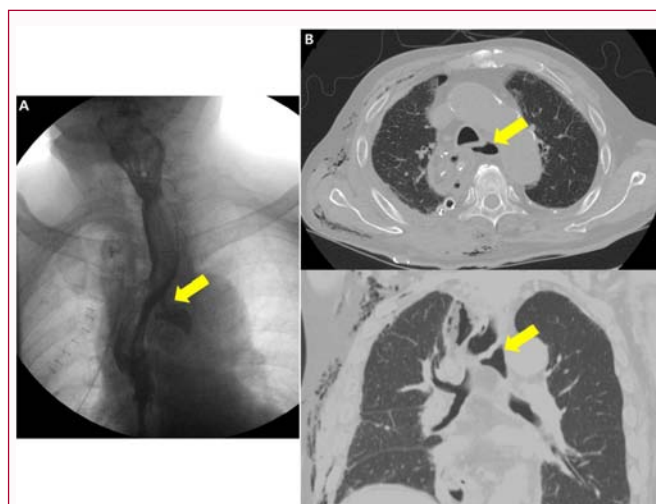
Radiologic images of esophageal anastomotic leak. (A) Water-soluble contrast esophagography confirming the presence of an anastomotic leak after an esophagectomy and sleeve esophago-gastric anastomosis. (B) Axial chest CT scan showing extraluminal air (arrow) near thoracic esophagus. (C) Coronal chest CT scan showing perforation of esophagus and cavitory lesion showing air-fluid level.
